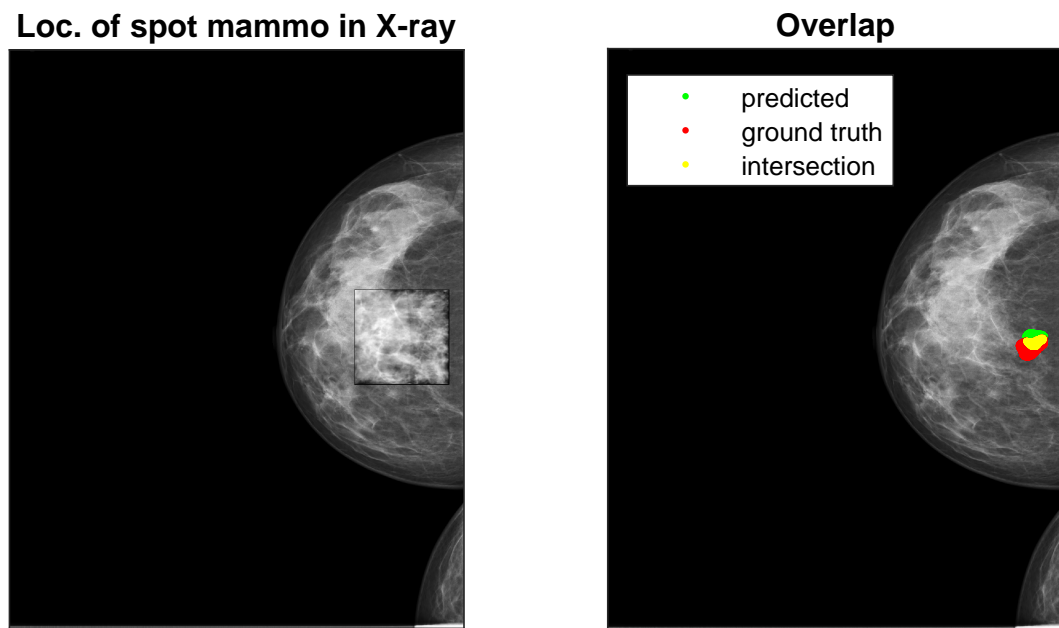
An example of registration between X-ray mammography and spot mammogram for the same showed case in the biomechanical model based registration (Patient ID 40): location of spot mammogram in full X-ray mammogram (left). Overlap between the lesion that has been annotated by radiologists in the original X-ray (red), prediction of the position of the lesion using image based registration (green), and overlap between the two lesions (yellow) (right).
